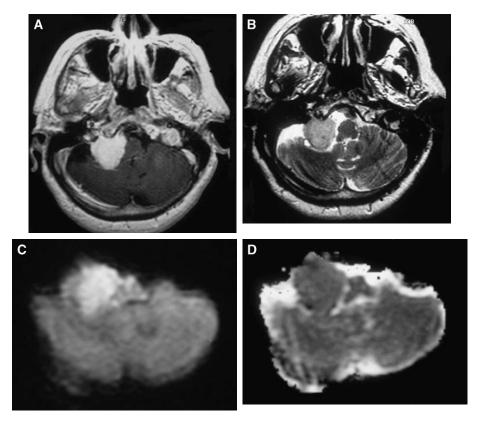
An 84-year-old woman with a meningioma. An axial, postcontrast-enhanced, T1-weighted image (A) and an axial T2-weighted image (B) show an extra-axial enhancing lesion in the right cerebellopontomedullary angle cistern. Axial diffusion-weighted imaging (C) shows "T2-shine through," whereas the apparent diffusion coefficient map (D) demonstrates isointense signal intensity suggesting cellularity similar to that of brain tissue.
